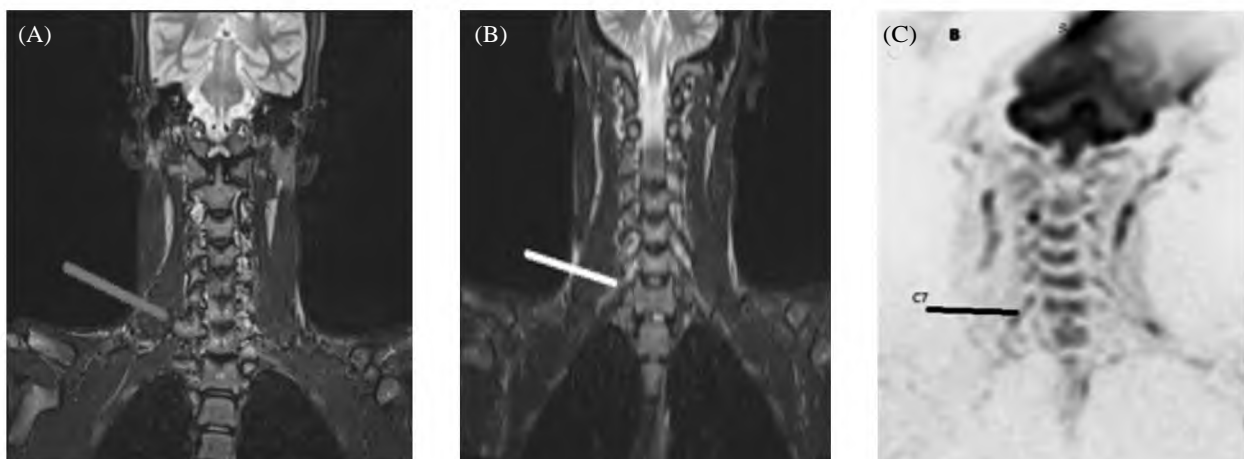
Male patient, 35 years old complained from right upper limb pain of 5 months duration. (A,B): Coronal 3D STIR, (C): Coronal DWI. Showing prominent right C7 transverse process (red line) in A, subtle edema of right C7 nerve root in B, with restricted signal of right C7 nerve root in C.
